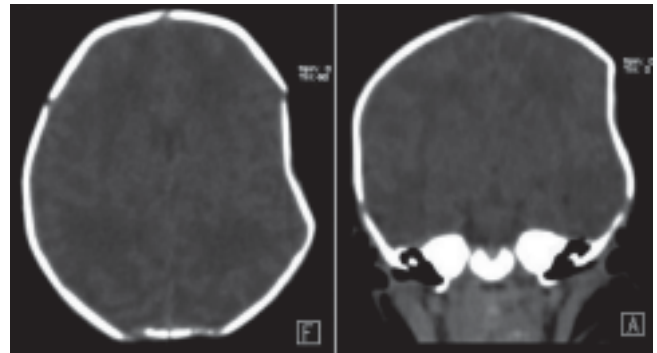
Axial computed tomography brain scan. Axial (A) and coronal section (B). It shows a depression in the left parietal region. The sinking depth is about 1.1 x 4.0 cm in extension, with no associated fracture.
